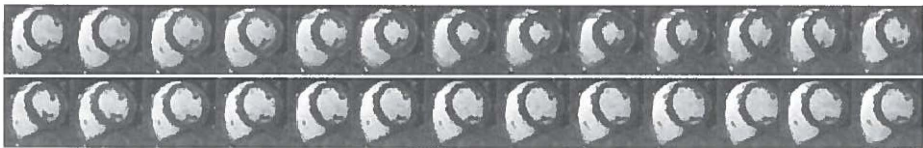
Complete cardiac cycle of a mid-ventricular short-axis slice acquired with retrospective gating. Representing the currently high temporal resolution of cine MR imaging, allowing for the detection of small alterations of systolic wall motion.
